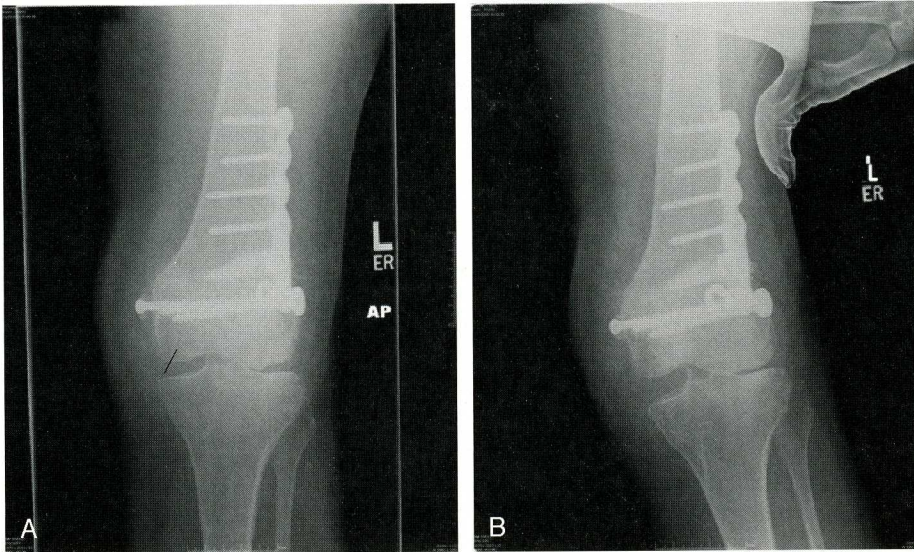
Anteroposterior plain radiographs at 0 degrees of flexion without (A) and with (B) valgus stress. Note that this patient had undergone a previous distal femoral osteotomy, anterior cruciate ligament reconstruction, and delayed MCL primary repair after a fracture/dislocation sustained in a skiing accident. The primary complaint was persistent valgus instability, as demonstrated (B), consistent with chronic MCL insufficiency.
